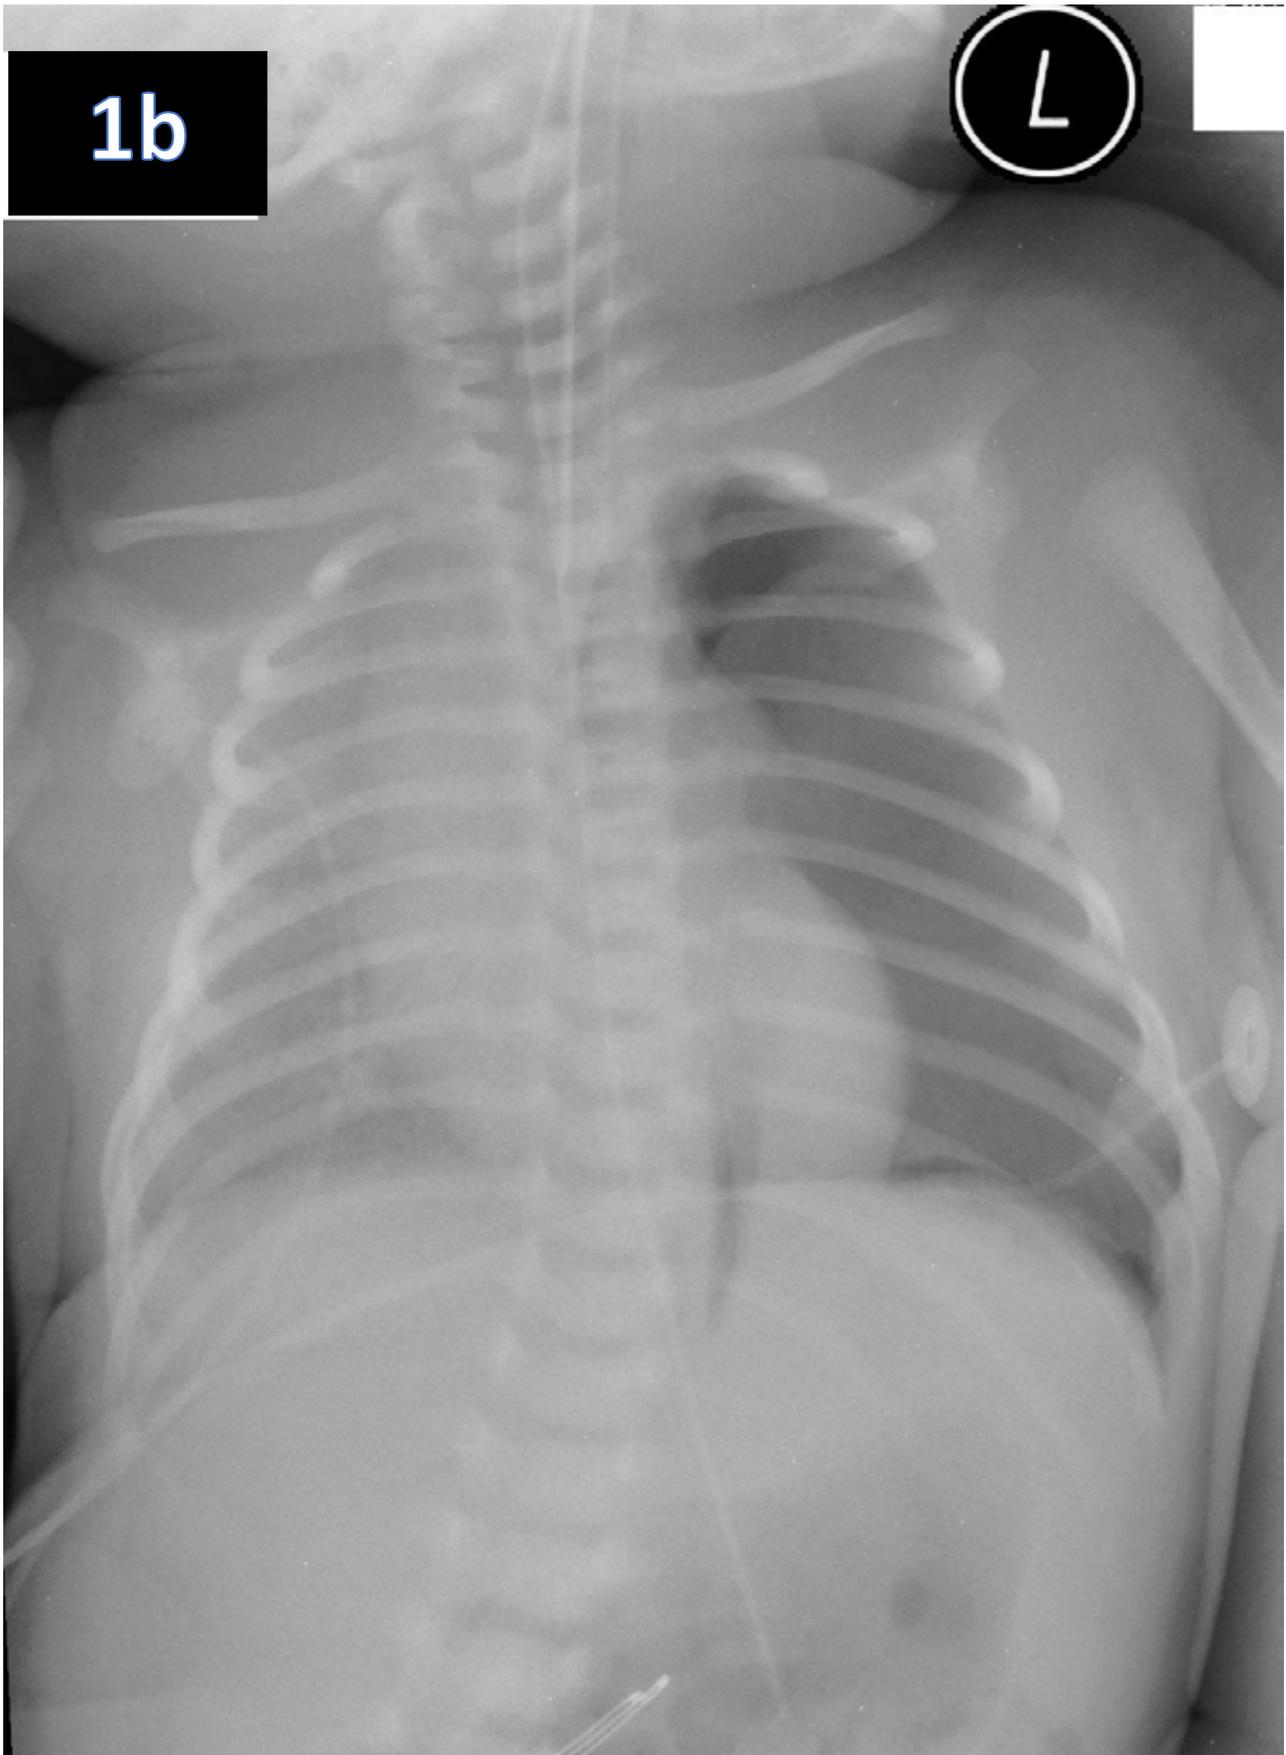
Chest x-ray repeated after 30 minutes showing well expanded left lung and with residual apical pneumothorax
